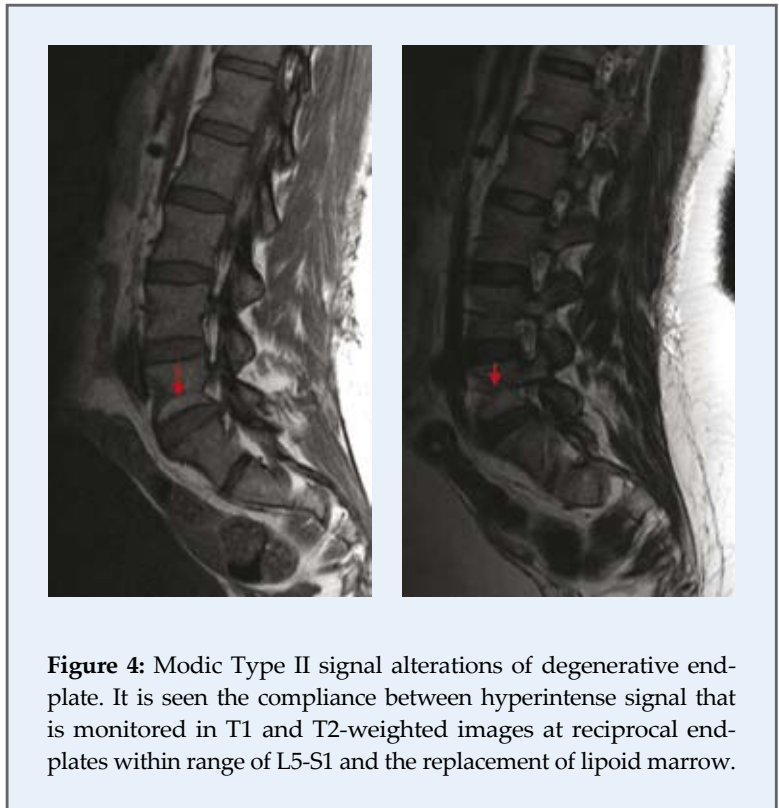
Modic Type II signal alterations of degenerative end-plate. It is seen the compliance between hyperintense signal that is monitored in T1 and T2-weighted images at reciprocal end-plates within range of L5-S1 and the replacement of lipoid marrow.
